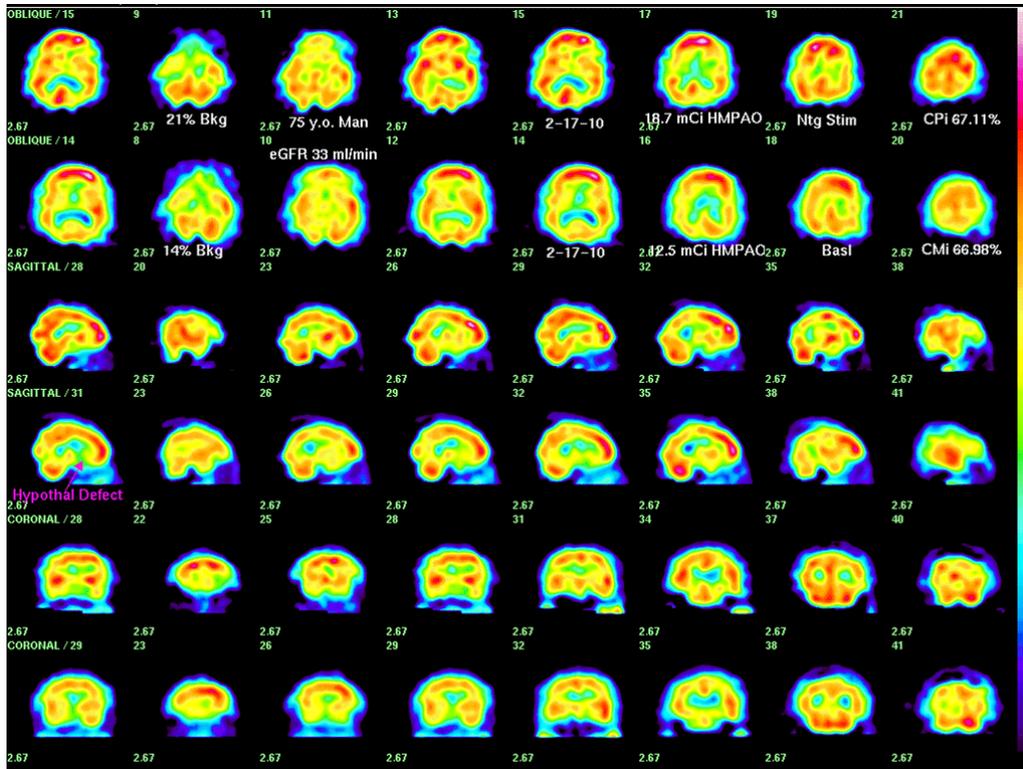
(above) Brain SPECT on the right used 0.8 mg nitroglycerin sublingual for perfusion-stimulated images (top row of each of 3 paired image rows; basal images are on the bottom) in a 75 year-old hypertensive man with relatively stable renal insufficiency: serum creatinine in the last 2 years 1.60 to 2.25 mg/dL, and near the time of imaging, 2.14 mg/dl, corresponding to GFR 33.9 ml/min. The patient has Mild Cognitive Impairment and cerebral flow reserve (CFi) 67.11 - 66.98 = 0.13%, abnormal vs. >1% expected. Realizing that renal disease (Rd) artifactually increases CFi in comparison to other patients with similar stroke risk, such as pituitary patients, we realized (American Association of Clinical Endocrinology, San Diego, May, 2011) that a nonlinear correction to the relation between flow and CPi was necessary for Rd. We discovered that a linear correction to the relation of GFR from the MDRD equation and a correction to CFi, viz. $c = 0.10(\text{GFR}) - 9.0$, where c is the correction for CFi, provided a good fit to the data. With this correction CFi = - 5.48 instead of +0.13%, similar to the mean CFi (-5.77+-4.97)% for 73 untreated pituitary patients. Overall among 95 Rd patients who had 113 scans, mean CFi (-1.27+-6.91)% correlated with 14/95 or 14.7% of Rd patients with stroke vs. 20/73 or 27.4% strokes among untreated Pd.
